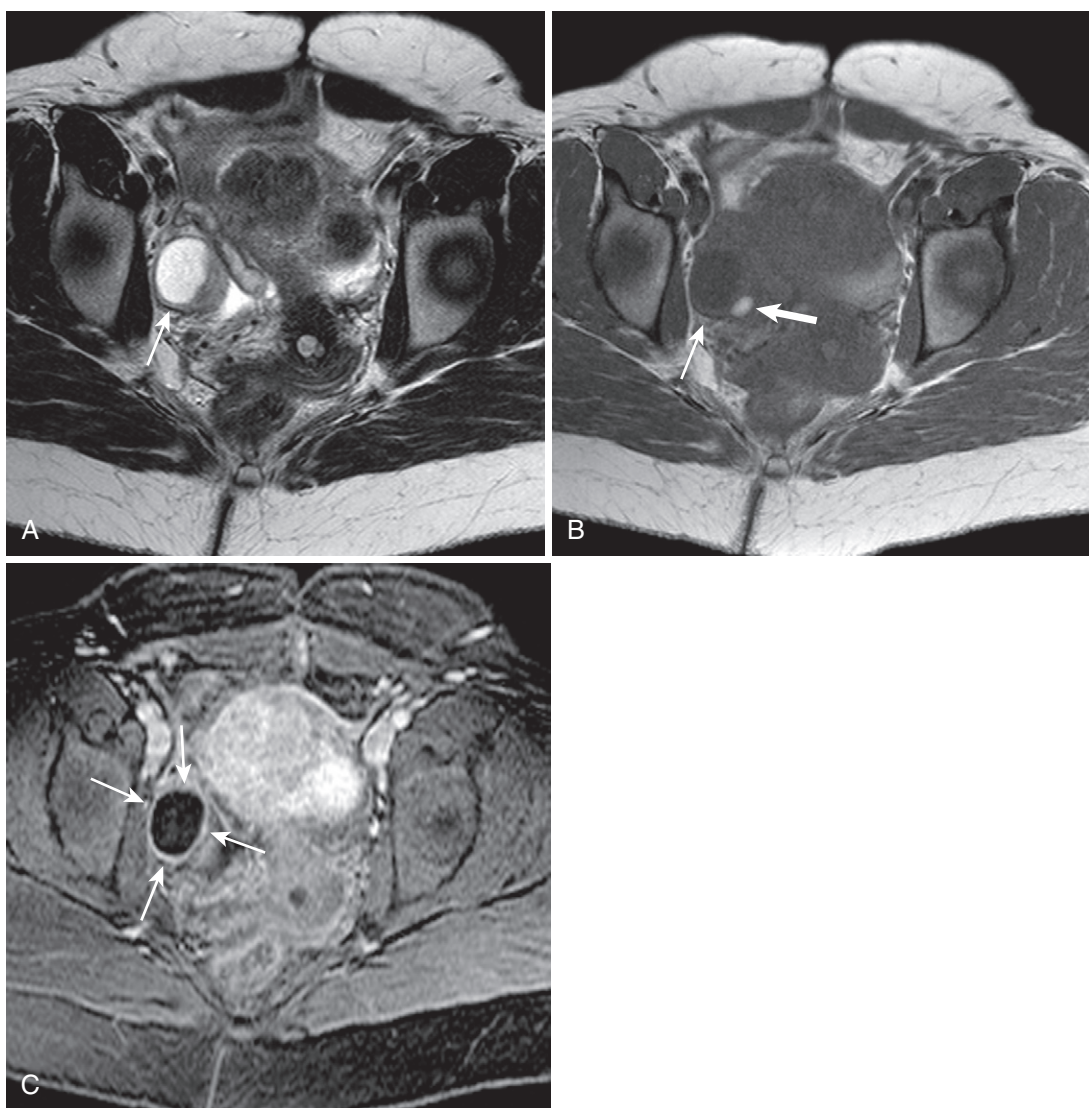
Corpus luteal cyst. Axial T2-weighted (A) and T1-weighted (B) images show a simple-appearing right ovarian cystic lesion (*thin arrow*) adjacent to a punctate lesion with inverted signal characteristics most typical of an endometrioma (*thick arrow*). C, Thin rim enhancement (*arrows*) clinches the diagnosis of corpus luteal cyst, assuming the appropriate attendant features (menstrual status, size ≤ 2.5 cm, and lack of obvious complexity).
